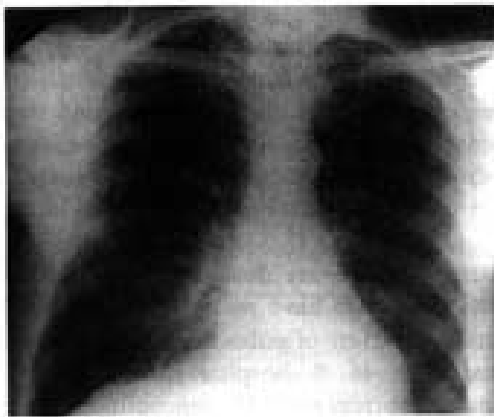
Chest x-ray showing a opacity in right lower lobe (Case 2).
